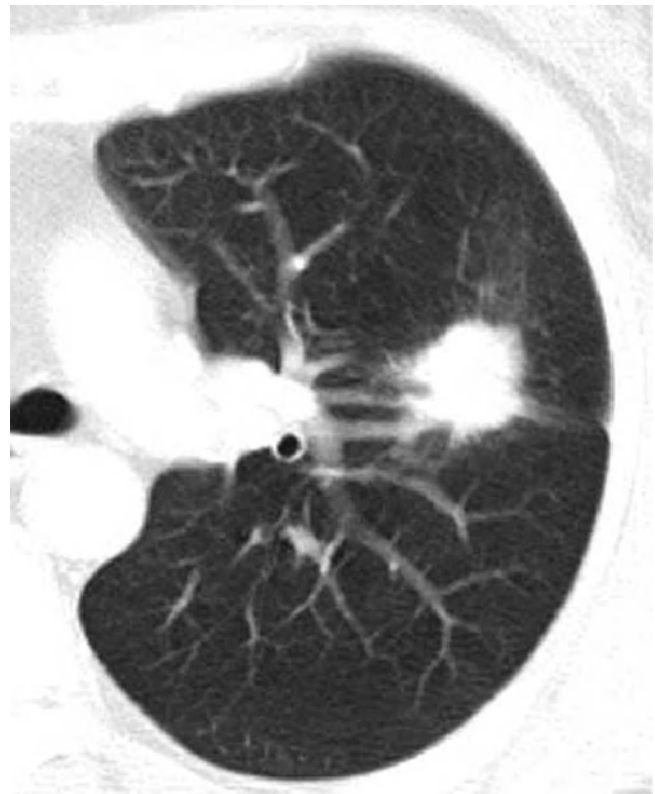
A lung nodule representing lung adenocarcinoma with acinar- and papillary-predominant subtypes in a 52-year-old woman. Thin-section (2.5-mm section thickness) CT scan obtained at level of tracheal carina shows a 22-mm-sized nodule with lobulated and spiculated margin in the left upper lobe
